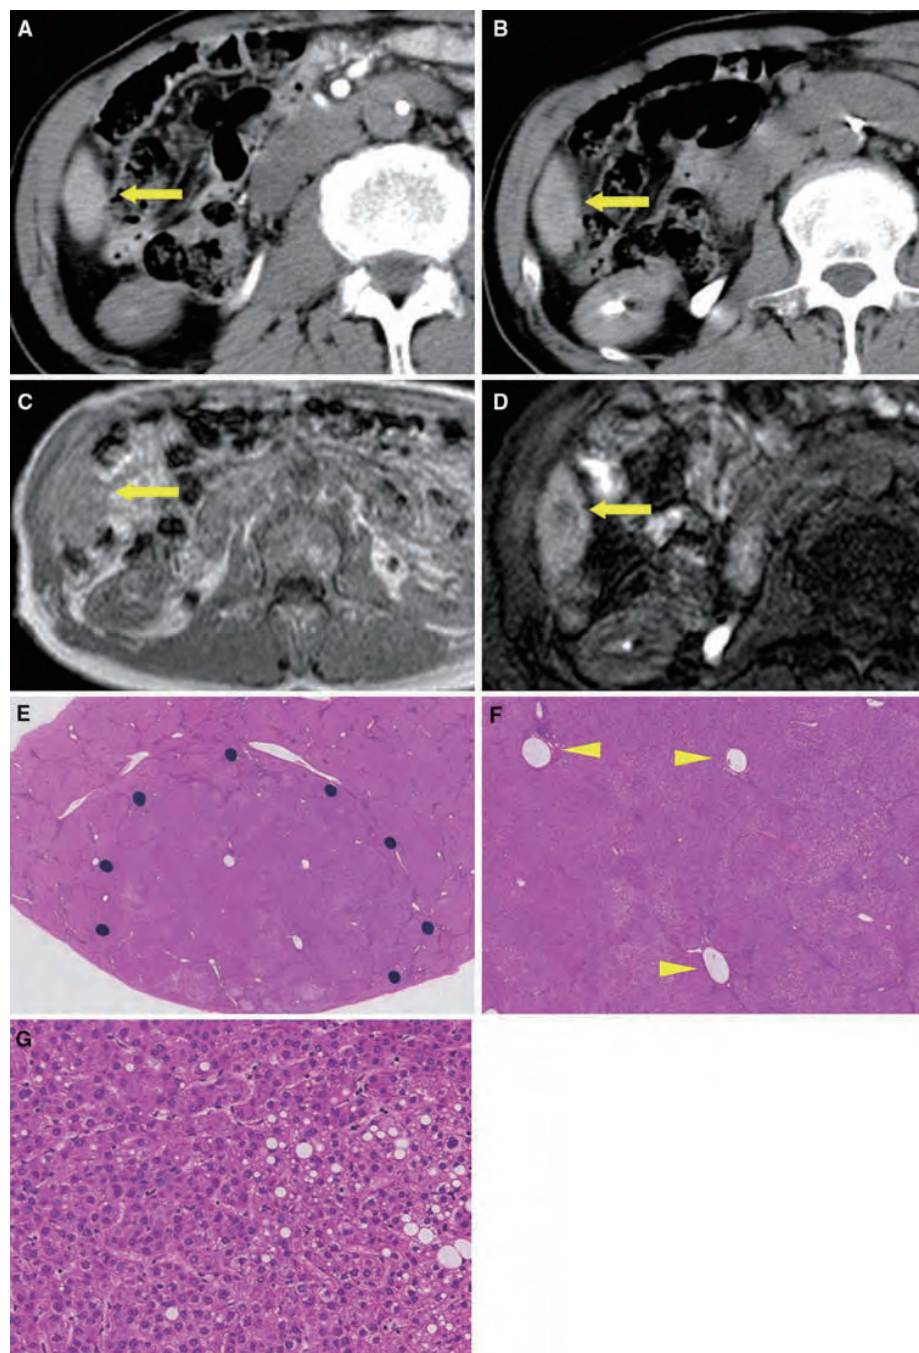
Case presentation of 69-year-old woman with early HCC. a, b The tumor showed isovascularity on arterial- and portal-phase dynamic CT scans. c Pre-contrast T1-weighted image showed slight high intensity (*arrow*). d Image 20 min after Gd-EOB-DTPA bolus injection. The tumor showed low intensity (*arrow*). The EOB
